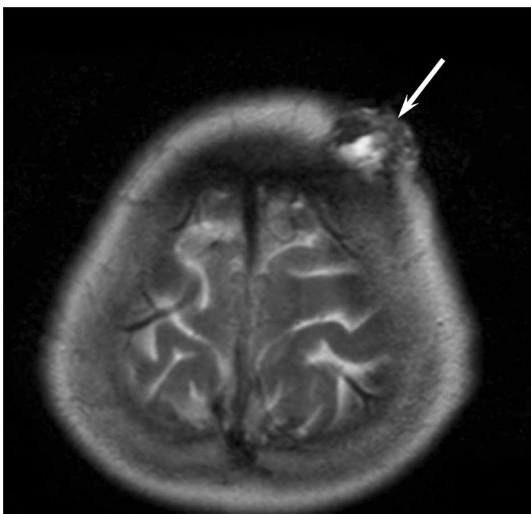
A 88-year-old man with angiosarcoma. T2-weighted image shows a heterogeneously hypo- to hyperintense lesion (arrow)
